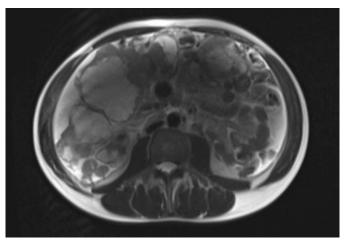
Abdominal MRI: the mass has high intensity on T2-weighted images.
